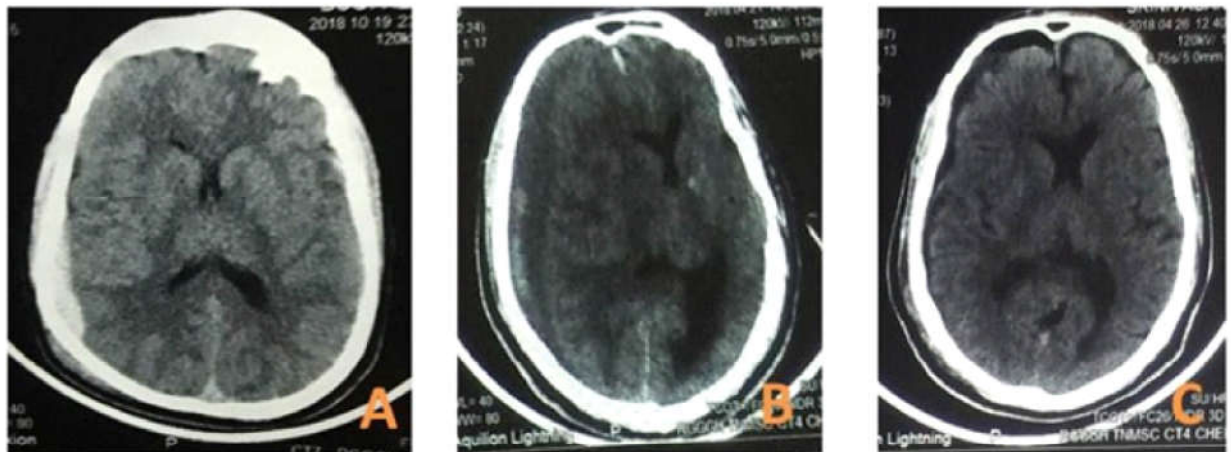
Case 3. CT scans of 54 year old female with history of RTA. A: on admission. B: on day 17. C: post burrhole evacuation.
